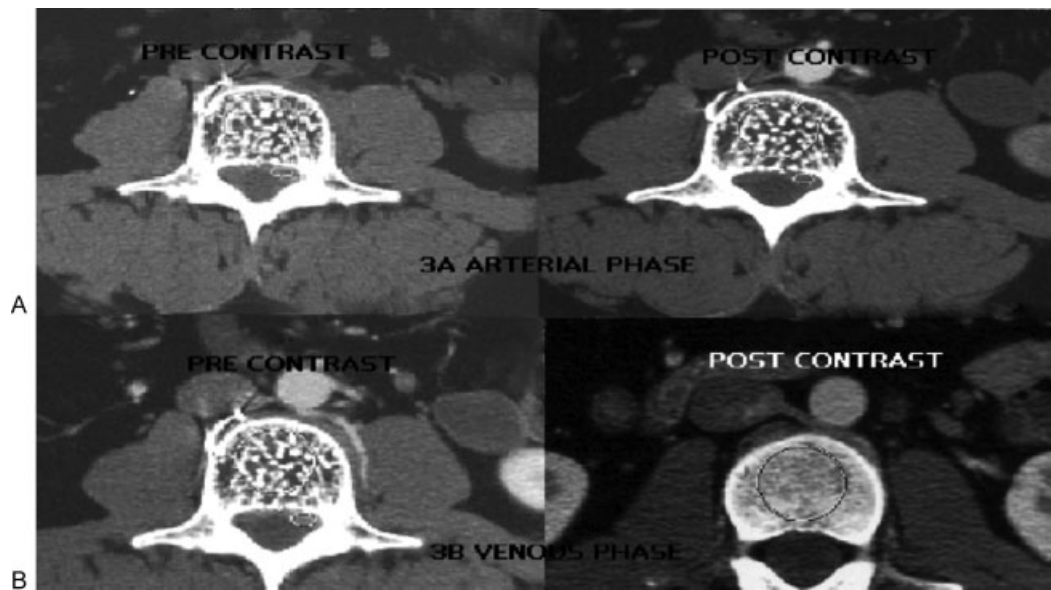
(A) Computed tomography (arterial phase) showing no filling with contrast postangiogram. (B) Computed tomography (venous phase) showing filling with contrast in venous phase.
